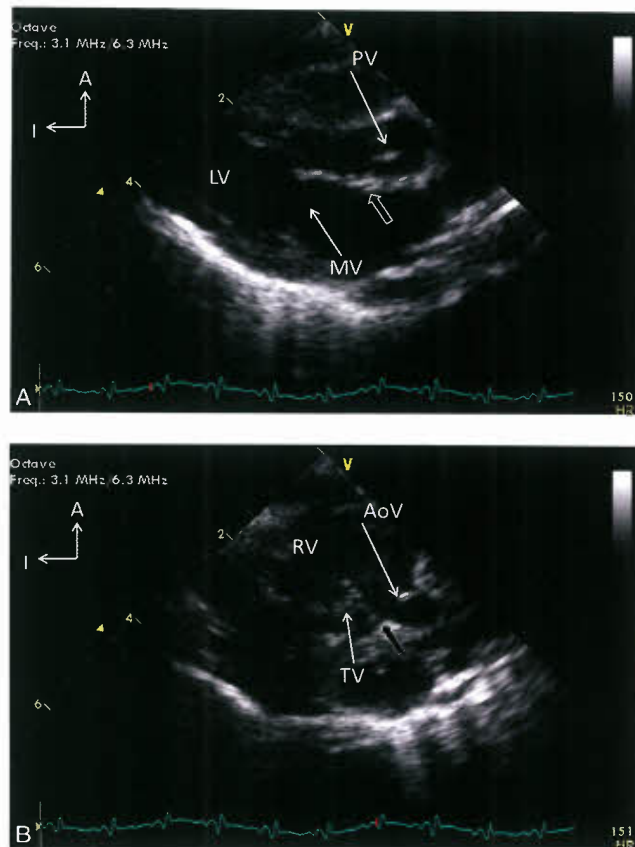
Parasternal long-axis images of a patient with bilaterally absent conus resulting in transposition of the great vessels (i.e., ventriculoarterial discordance) with not only mitral-pulmonic continuity (arrowhead in standard parasternal long-axis view (A) but also tricuspid-aortic continuity (arrowhead in parasternal long-axis view swept right and inferiorly (B)). A, anterior; AoV, aortic valve; I, inferior; LV, left ventricle; MV, mitral valve; PV, pulmonary valve; RV, right ventricle; TV, tricuspid valve.
